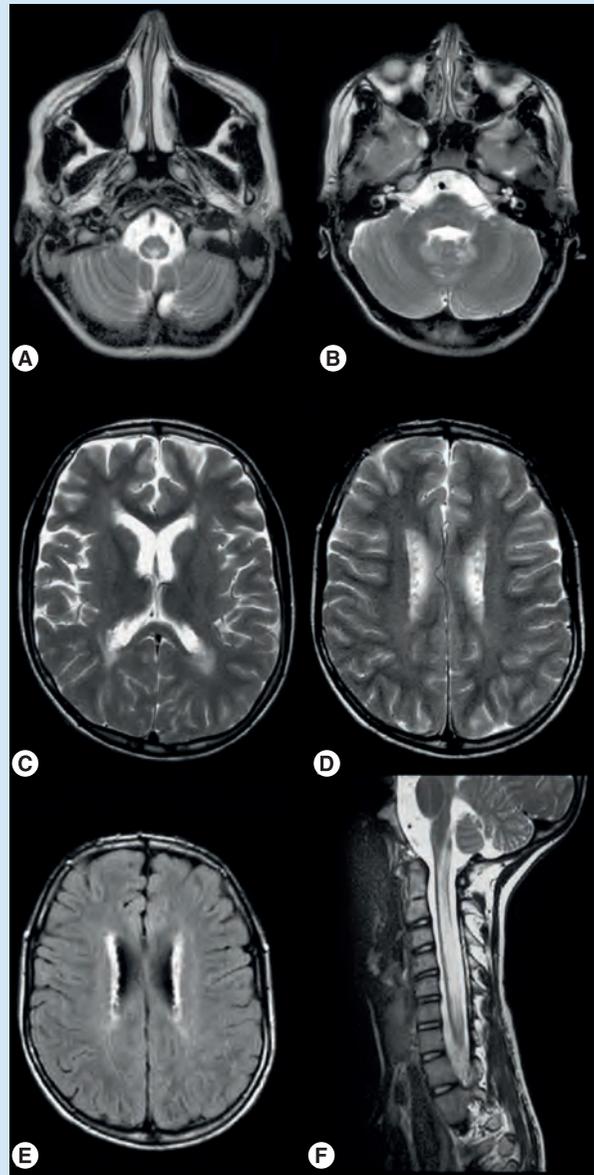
MRI in juvenile Alexander disease. (A) Signal abnormalities in the medulla, (B) the hilus of the dentate nucleus, and (C) a thin periventricular rim. (D & E) Peculiar garland-like structures are present along the ventricular wall. (F) Swelling and prominent signal abnormality of the cervical spinal cord. Reproduced with permission from [78]. © 2006, Wolters Kluwer Health.
